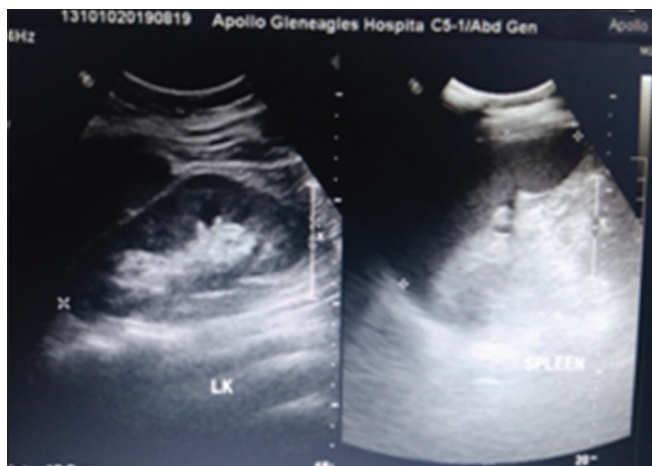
Ultrasonography on day 1 of the first admission showing mild splenomegaly
